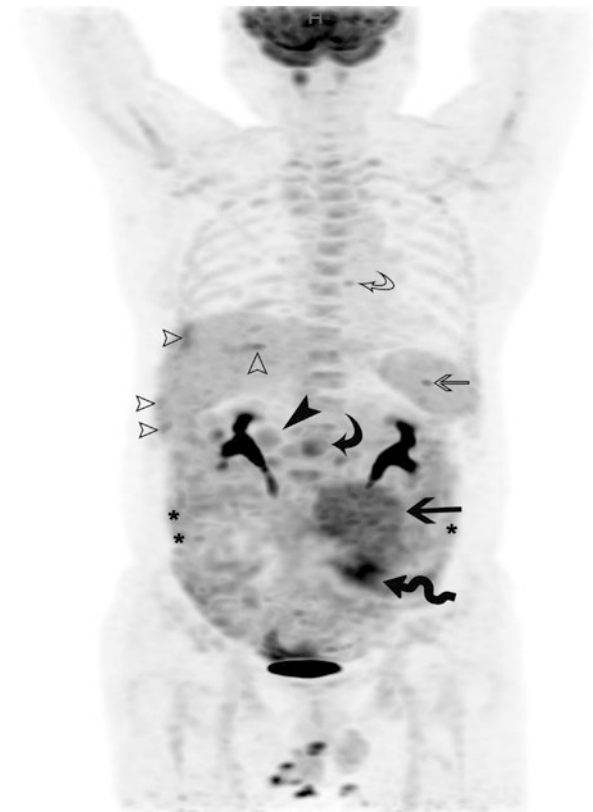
Acute myeloid leukemia (AML) with granulocytic maturation (M2) with extramedullary presentations. The maximum intensity projection (MIP) image of the baseline PET scan demonstrates marked accumulation of ^{18}F FDG in the descending part of the duodenum (myeloid sarcoma; SUV_{max} 6.7; solid arrowhead), localized walls of the small intestine (the left middle abdomen: SUV_{max} 11.4; solid wave arrow), mesenteries (the left middle abdomen: SUV_{max} 9.1; solid arrow; the middle abdomen: solid curved arrow), greater omentum (asterisk), peritoneum (the perihepatic area: open arrowhead), rectovesical pouch, the left anterior intercostal region between the sixth and seventh ribs (open arrow), multiple lymphadenopathies in the retroperitoneal cavity, the right pleura, the area of the bilateral internal mammary arteries (the left side: open curved arrow), and the bilateral suprarenal regions, and diffuse increased accumulation of ^{18}F FDG in the thoracic and lumbar vertebrae, the proximal ends of the bilateral humeri, multiple bilateral ribs and thoracic and lumbar vertebrae, and pelvis (AML). Note: urine contamination of ^{18}F FDG in the perineal region
